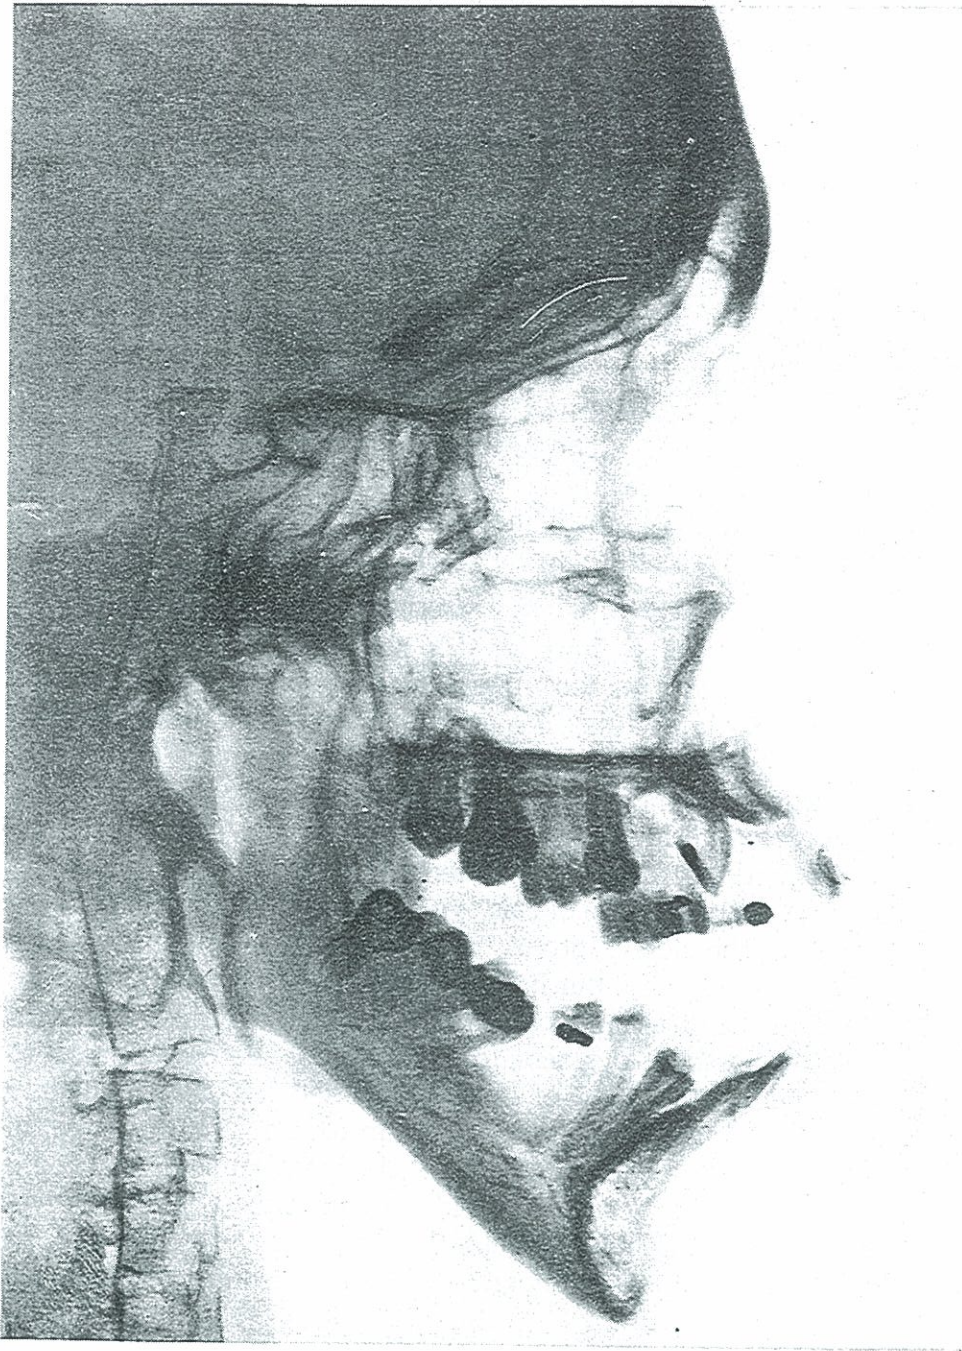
ROENTGENOGRAPHIC VIEW SHOWING THE FREE MOVEMENT OF MANDIBLE WHICH BEFORE DENTAL EXTRACTIONS WAS ANKYLOSED CLOSED.
